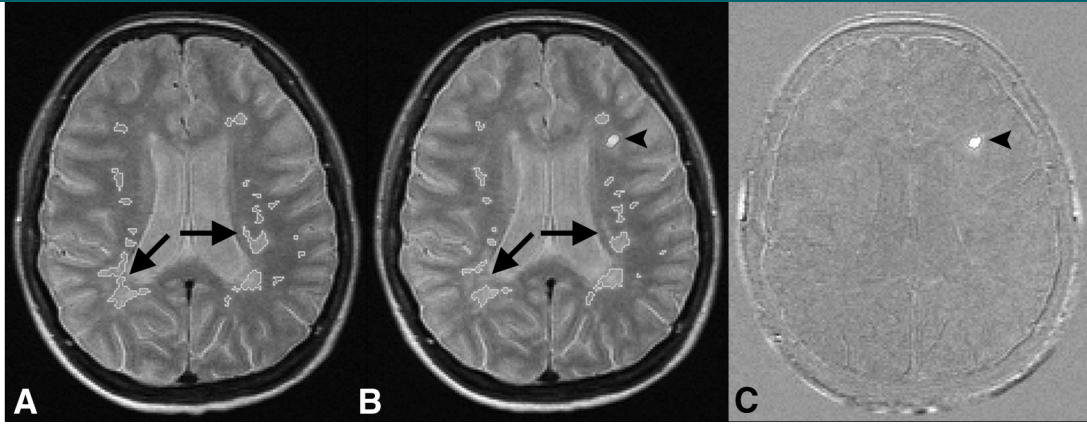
MR images show example of variability in lesion outlines for lesion load measurements on native images. *A*, Native baseline PD-weighted image (2000–3000/60–100). *B*, Native follow-up PD-weighted image. *C*, Subtraction image. Lesions do not change (except for one new lesion), but lesion outlines (of stable lesions) do show variability (arrows), which decreases precision and, subsequently, power to detect treatment effects on native images. Subtraction images circumvent this problem, as only active lesions (arrowheads) are displayed, allowing direct quantification of change.
